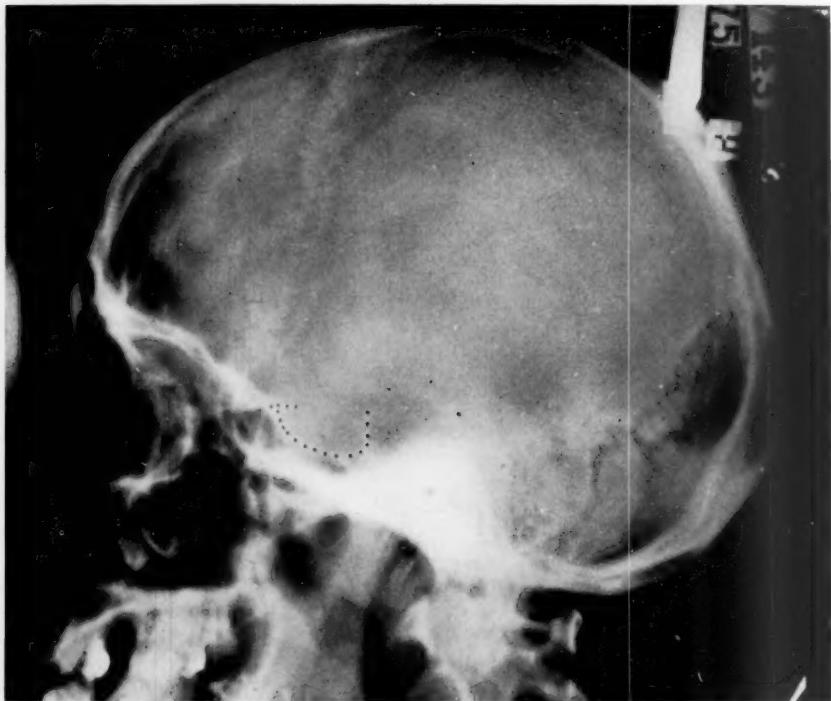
X-ray of skull showing much enlarged sella turcica.
